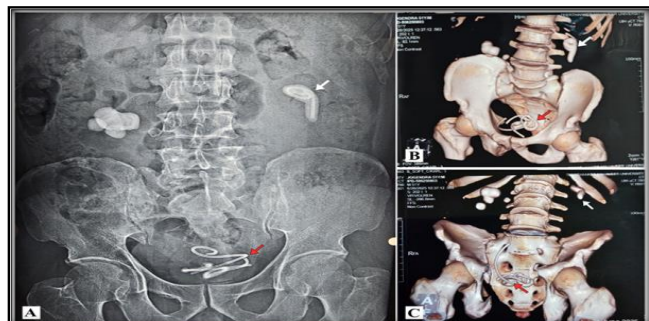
Part A. X-Ray Abdomen showing multiple stones in bilateral kidneys. White arrow depicts the stone formation around fragmented proximal head of DJ Stent. Red arrow points the rest of the coiled loop with distal head of DJ Stent. Parts B., & C. CT Urogram shows the stone fragments in 3D imaging.
